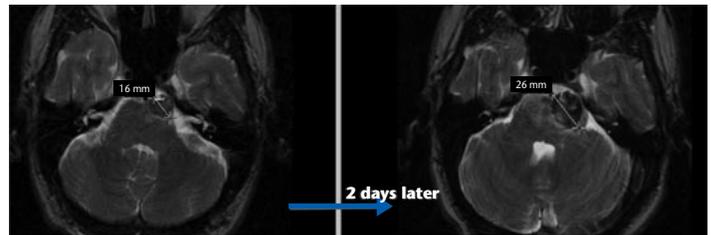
A and B. The admission MRI compared with the MRI repeated two days later demonstrates significant expansion of the lesion from 16 mm axial diameter to 26 mm axial diameter.
